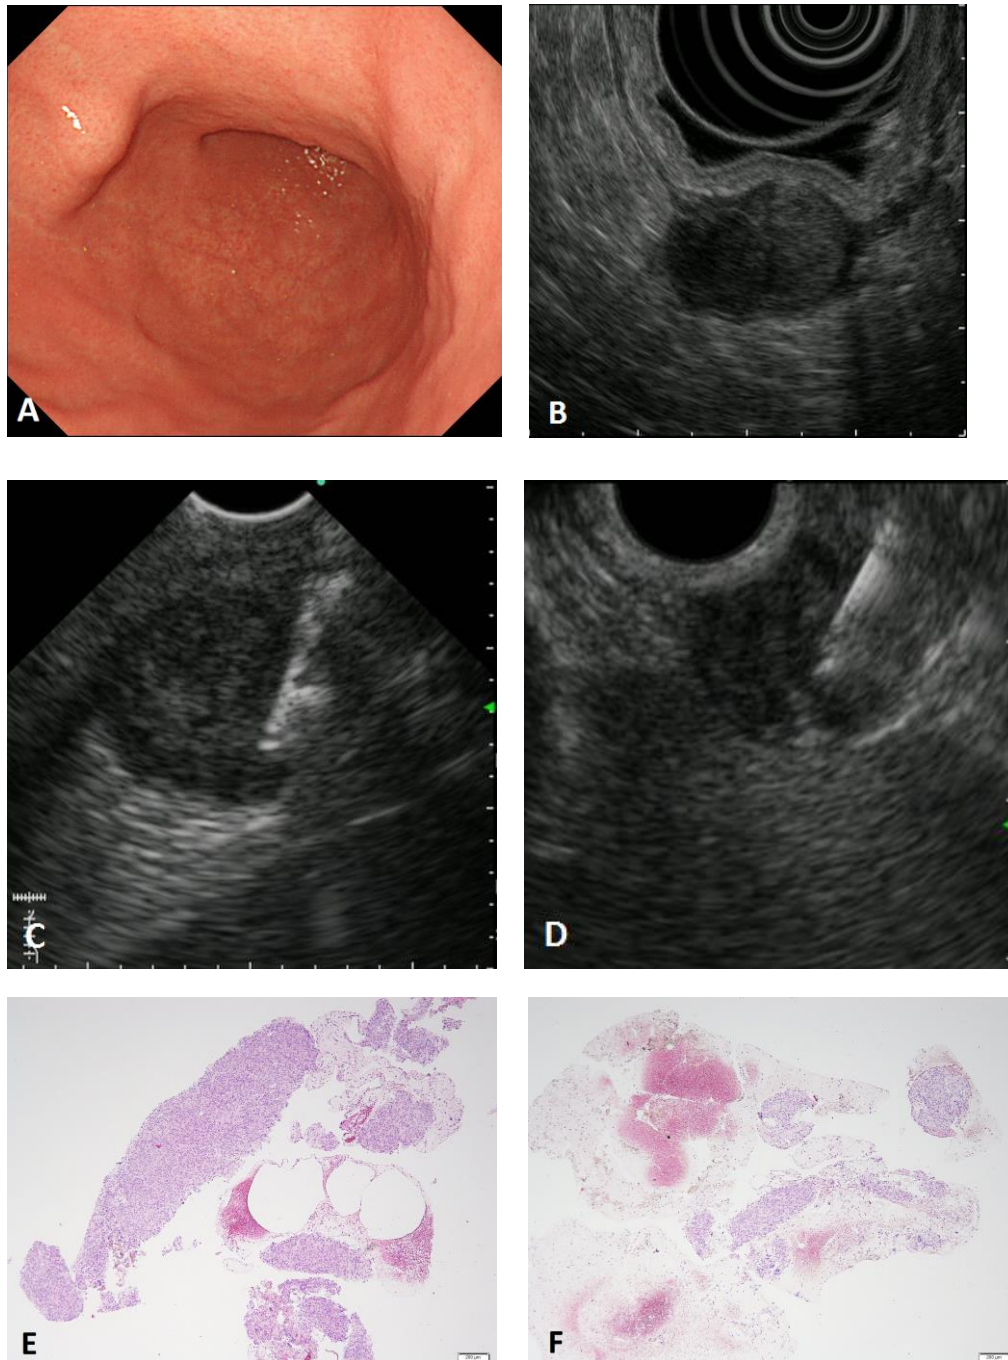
Representative case of a gastrointestinal stromal tumor. A, Endoscopy showing subepithelial lesion in the lower body of stomach. B, Endoscopic ultrasound image with radial scanner. The hypoechoic tumor was 17 mm and had a heterogeneous echo pattern, irregular border, and was localized in the muscularis propria. C, Puncture of the tumor under direct endosonographic visualization with a 19-gauge needle using the forward-viewing echoendoscope. D, Puncture of the tumor with 22-gauge needle using the oblique-viewing echoendoscope. E, Abundant tissue fragments were obtained using
